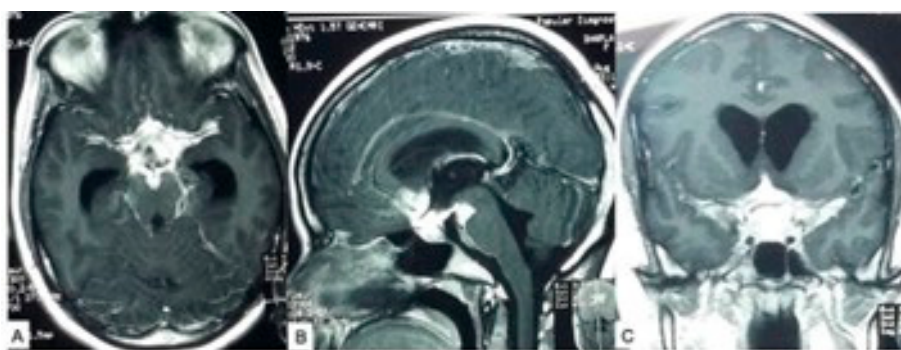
(A–C) Contrast MRI axial, sagittal and coronal image showing basal tubercular meningitis with a granuloma. Source: Figure by authors.
